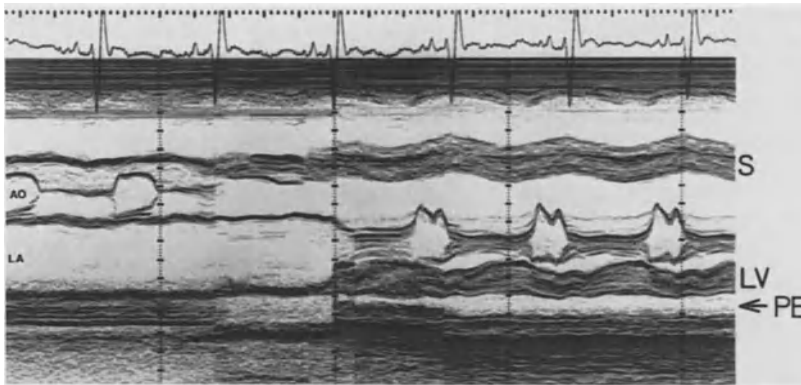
M-Mode echocardiogram in posterior pericardial effusion (PE), which disappears behind the left atrium.
